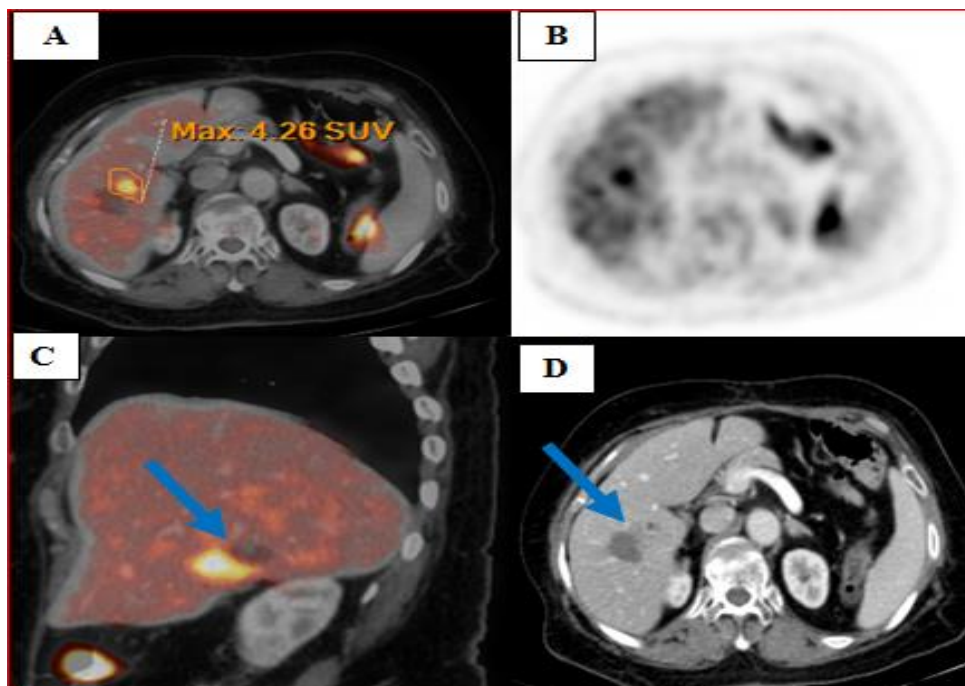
70years old male patient with history of HCC diagnosed with typical enhancement criteria of HCC by triphasic CT and elevated alpha fetoprotein (155ng/ml) underwent radiofrequency ablation, referred for PETCT I month later after RFA.
